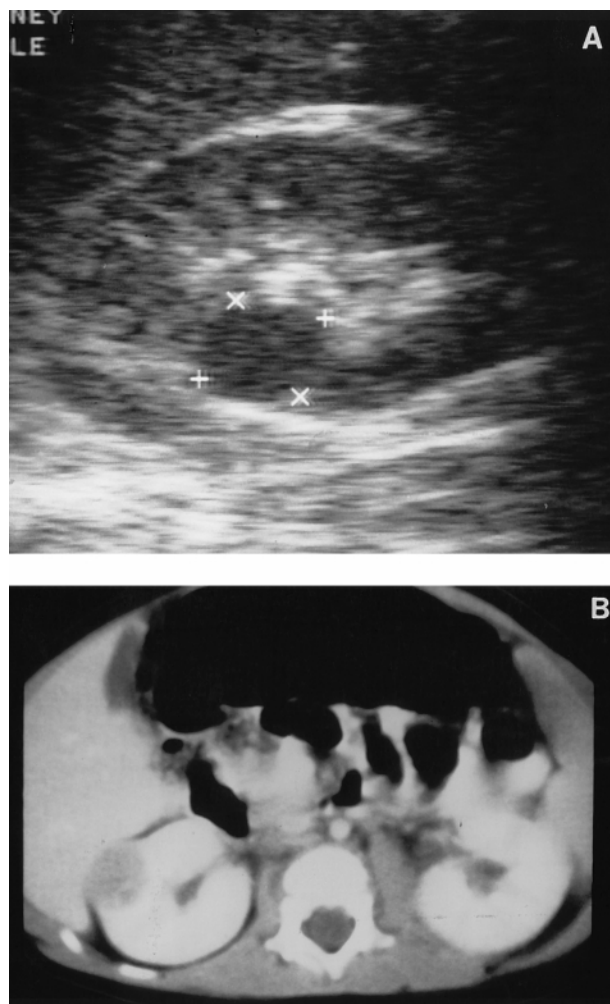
Eighteen-month-old boy with BWS. Screening ultrasonography (A) shows small Wilms' tumor in right kidney that is confirmed on the CT (B). This tumor is amenable to partial nephrectomy.
